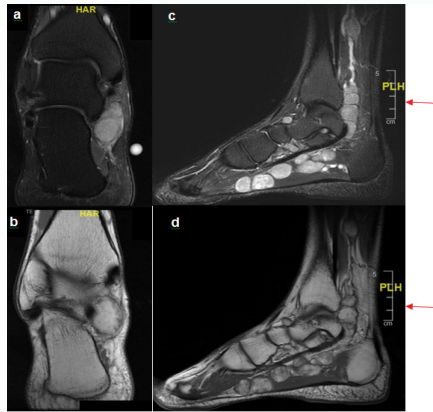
Multiple schwannomas. A, B) Coronal MRI images. C, D) Sagittal MRI images. A) STIR image shows homogeneous high-intensity lesions (arrow) located inferomedial to medial malleolus. B) T1-weighted image shows the lesion (arrow) as nodular and low-intensity. C) STIR image shows numerous well-defined high-intensity masses (stars) dependent on the posterior tibial nerve (arrow). D) T2-weighted image shows that these masses (stars) extended along the path of this nerve (arrow), from the distal third of the posteromedial aspect of the tibia to the base of the first metatarsal.
